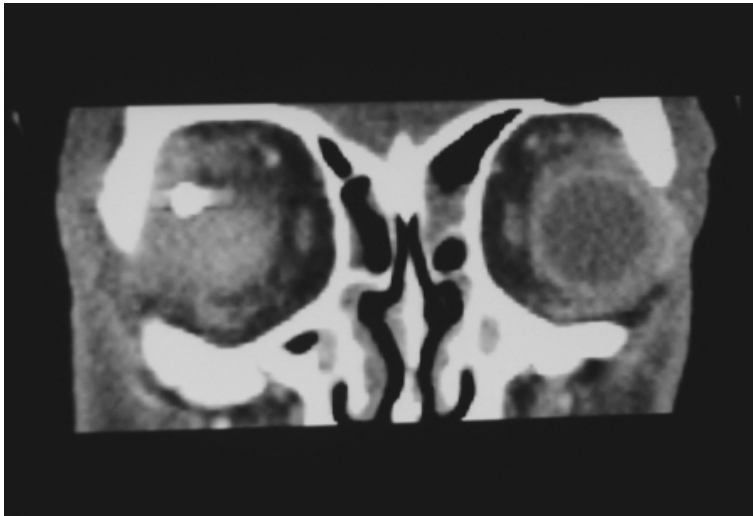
Intraocular metallic foreign body on CT scanning
